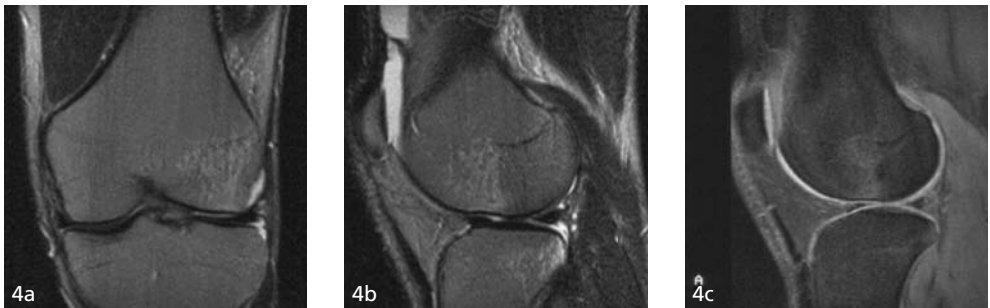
4a-c Coronal and sagittal T2-weighted (respectively 2100/80 and 2350/80) image and sagittal frequency-selective fat suppressed T1-weighted (70/13; flip angle 45°) image of bone bruise in lateral femoral condyle and lateral tibial plateau in a 26 year old patient 2 months after sports injury. Arthroscopy showed a medial meniscal tear and partial ACL rupture.
